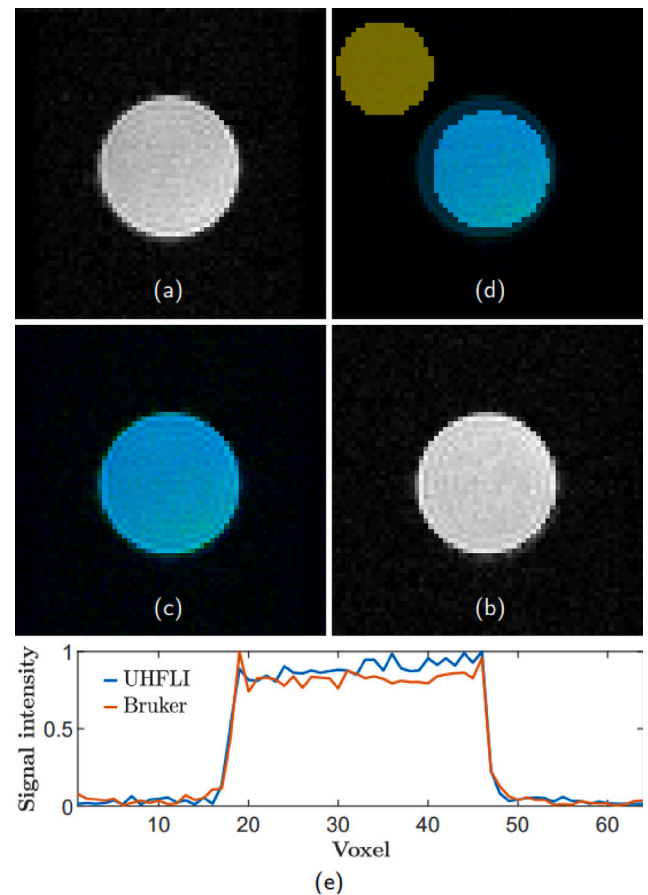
(a)  $^1\text{H}$  MRI of a 10 mm tube filled with distilled water acquired via the UHFLI. (b) MRI of the same sample acquired via the Bruker receiver. (c) Overlaid images ( $[R, G, B] = [0, (a), (b)]$ ) show exact size of the two images. (d) Signal and noise regions that were chosen for SNR calculation. FOV =  $20 \times 20 \text{ mm}^2$ , slice thickness = 5 mm, flip angle =  $30^\circ$ , image size =  $64 \times 64$  pixels, image bandwidth = 50 kHz. (e) Center line of images (a) and (b).
